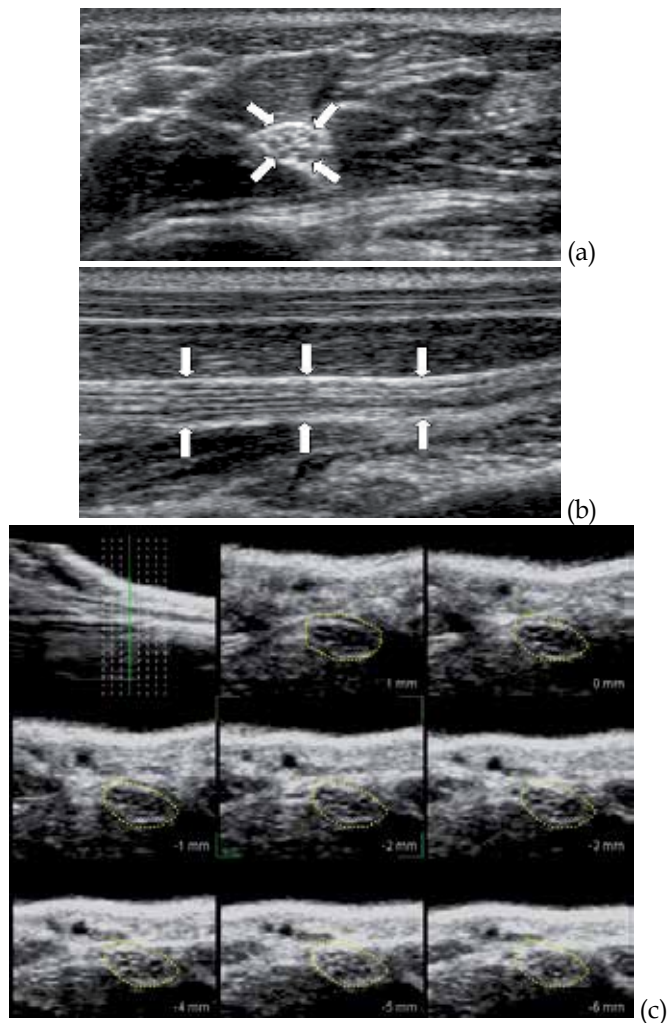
Sonographic imaging of the median nerve. Transverse sonogram of the median nerve in 5cm proximal to the wrist (a), and longitudinal sonogram of the median nerve (b). Multi-slice views using three-dimensional volumetric ultrasonography images (c). The transverse planes at continuous segment of the median nerves are visualized.
